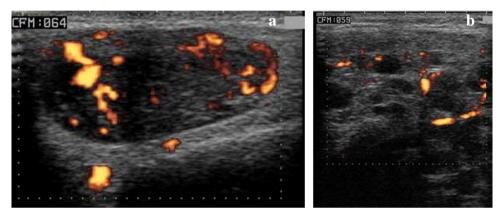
PIRADS 2: (A) Pattern four (benign unifocal pattern): ultrasound of the parotid gland shows well-defined oval focal lesion with homogeneous echo pattern and vascularity at power Duplex. (B) Pattern five (multifocal pattern): Ultrasound of the parotid gland shows multiple rounded, well defined scattered focal lesions within parotid parenchymal in patient with Sjögren's syndrome.
